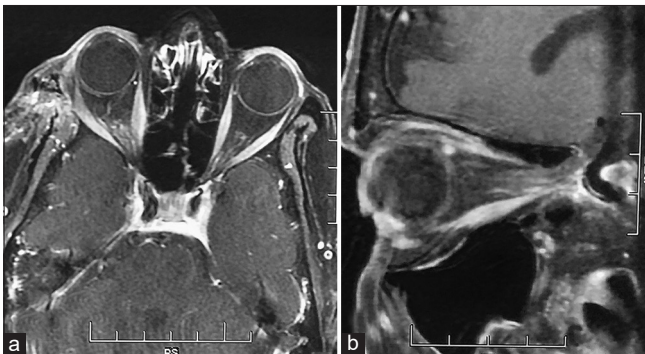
(a-c) Preoperative MRI images showing heterogeneous contrast enhancing intraorbital mass in the right eye with proptosis.
